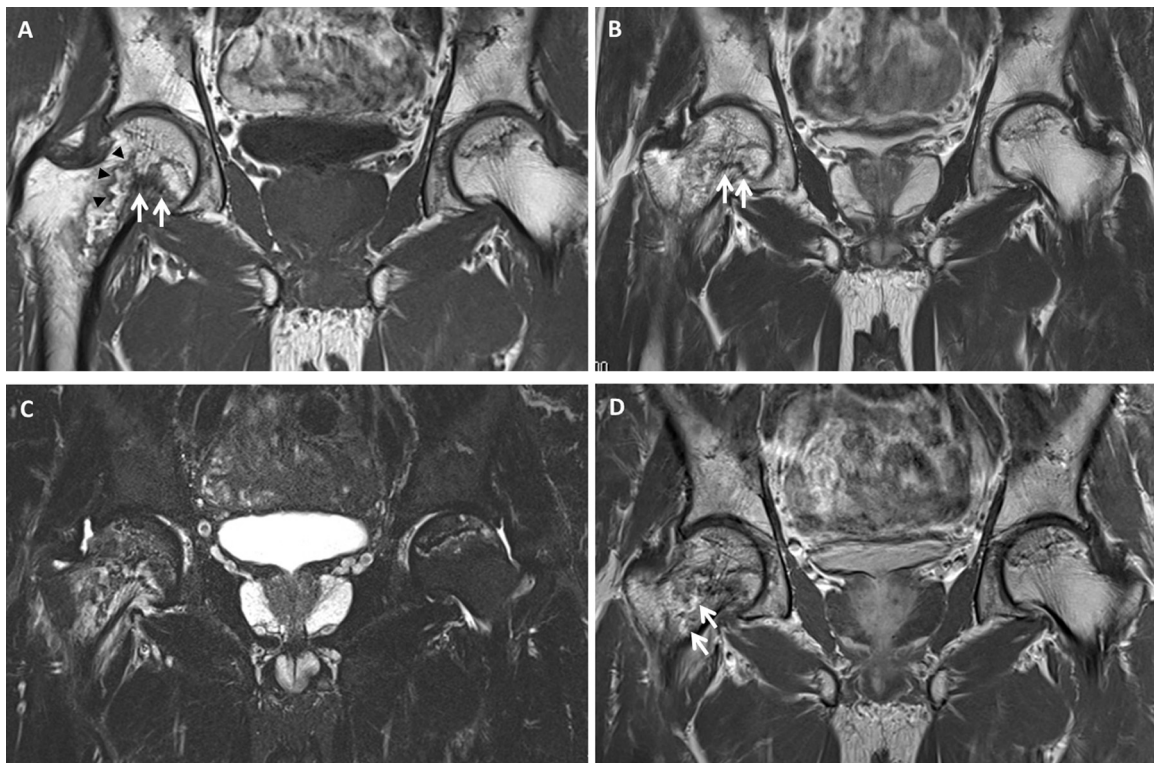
Coronal *T*₁-weighted (A) and *T*₂-weighted (B) magnetic resonance images show a thick low-signal-intensity band at the medial part of the femoral neck (white arrows). Furthermore, the irregular, serpentine, low-signal-intensity lesion extended and descended to the intertrochanteric area on *T*₁-weighted images (black arrowheads). A coronal short τ inversion recovery sequence (C) shows an edema pattern in the bone marrow of the right femoral neck. A coronal gadolinium-enhanced *T*₁-weighted magnetic resonance image (D) shows no contrast enhancement in the proximal segment from the distal low-intensity band. The proximal low-intensity band is not contrast-enhanced, but the distal low-intensity band is partially contrast-enhanced (white arrows).
